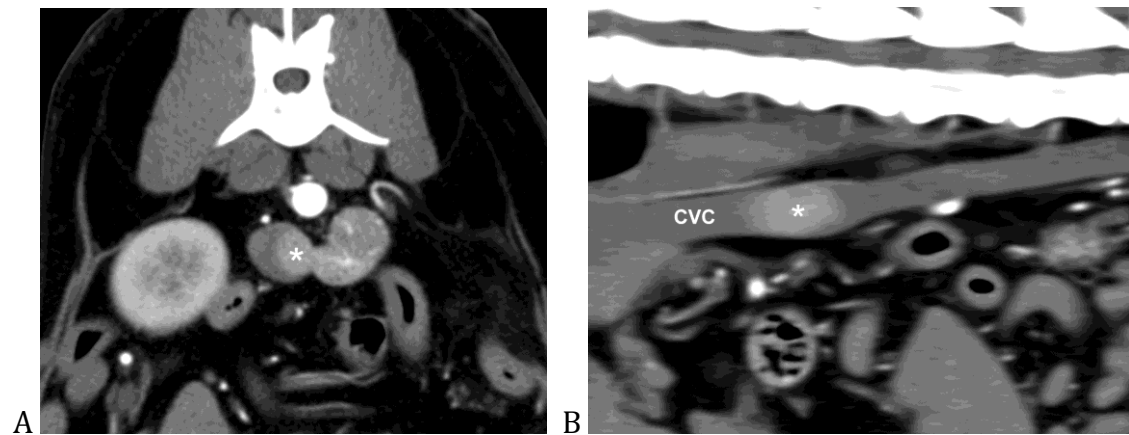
A) Transverse and B) sagittal post-contrast CT images showing vascular invasion of a left adrenal mass. There is a contrast enhancing mass (*) within the lumen of the caudal vena cava (CVC).
